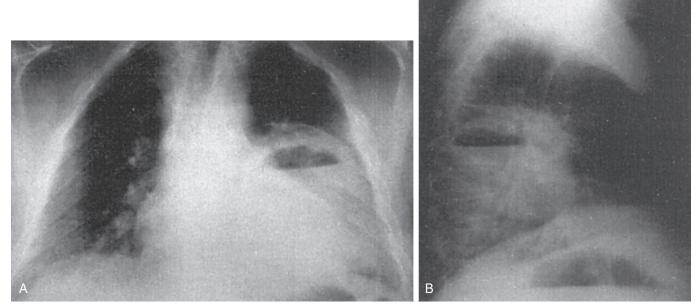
Posteroanterior (A) and lateral (B) chest radiographs reveal a lung abscess in the left lower lobe, with a distinct air-fluid level.
